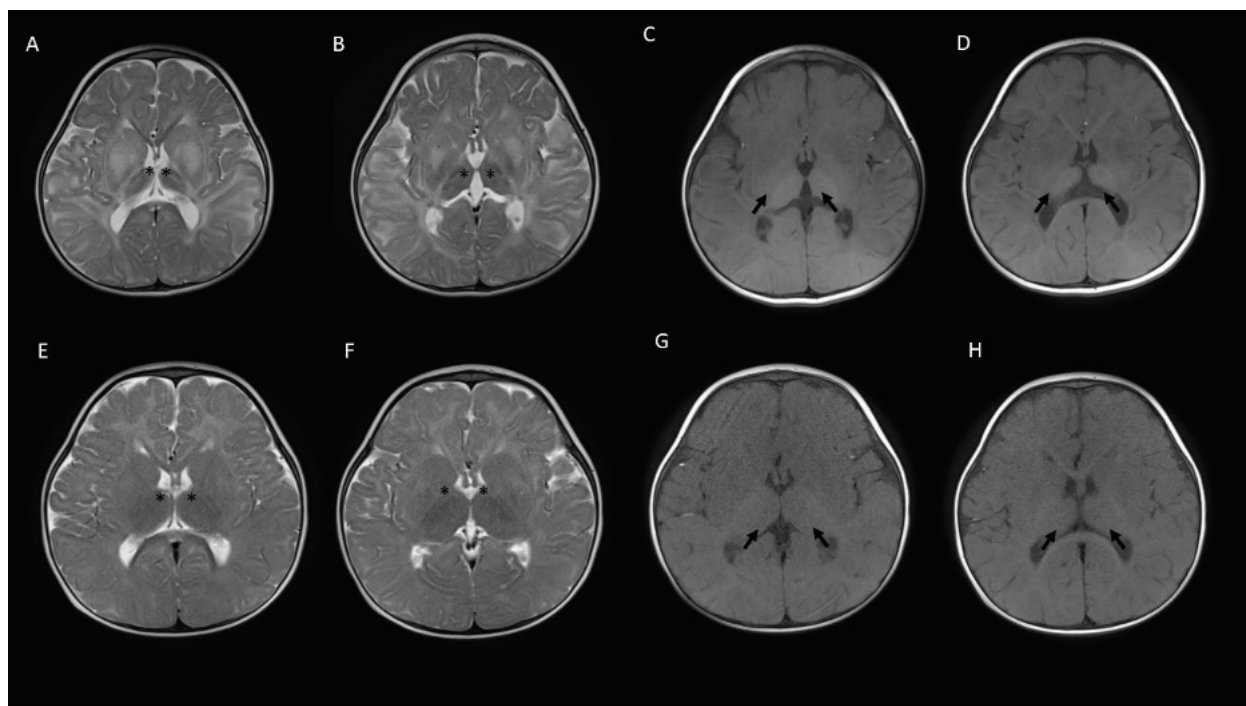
Cranial MRI findings in case 5 with TSD. At the age of 13 months (A-D), sagittal T2-weighted (T2W) images showed hyperintense signal changes in thalami in A,B (black asterisk) and sagittal T1W images showed hypointense signal changes in thalami in C,D (black arrow). At the age of 8 months (E-H), sagittal T2W images showed minimal hyperintense signal changes in thalami in E,F (black asterisk) and sagittal T1W images showed minimal hypointense signal changes in thalami in G,H (black arrow)
